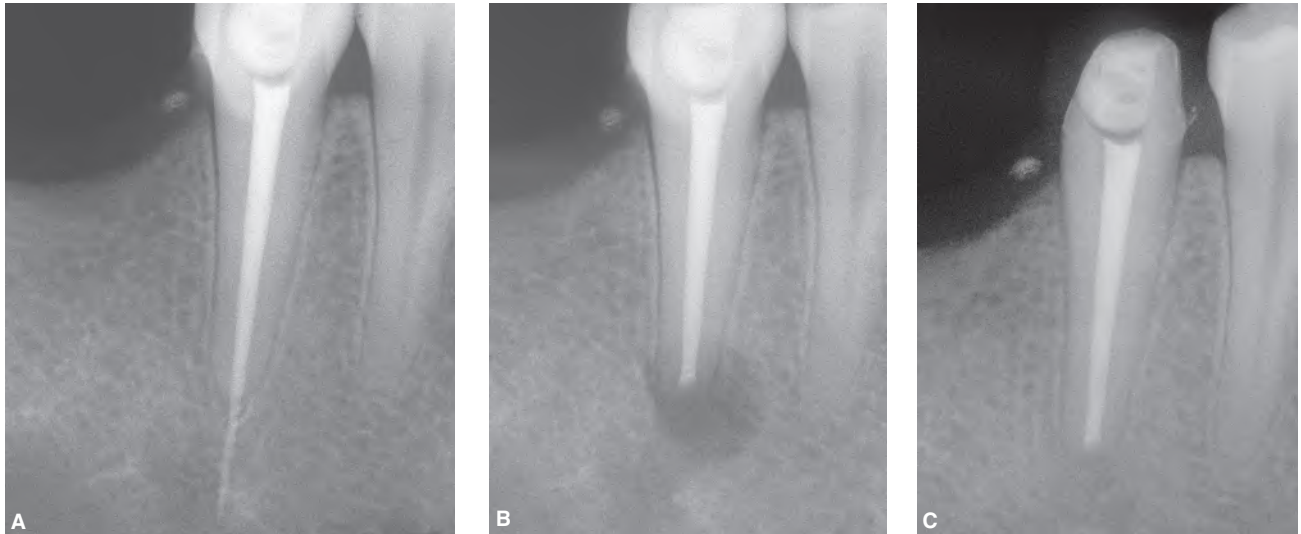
Excess of obturation material is an indication for surgical treatment if it does not seal the root canal system, or if it has been pushed against anatomical structures and the patient is symptomatic. In this case, the gutta-percha cone was pushed against the mental nerve and the patient developed paresthesia. A. Preoperative radiograph. B. Radiograph taken immediately after the apical surgery. Ultrasonic tips (piezoelectric surgery) were used since high speed burs could have further damaged the nerve bundle. Two weeks after the surgery the paresthesia disappeared completely. C. 2-year follow-up radiograph. The patient was asymptomatic and paresthesia did not recur.
